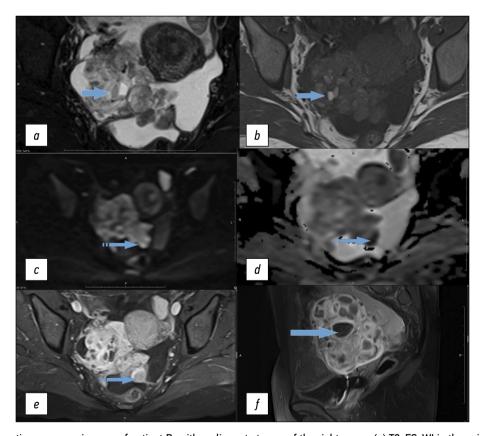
Pelvic magnetic resonance images of patient R. with malignant struma of the right ovary: (a) T2-FS-WI in the axial plane; (b) T1-WI in the axial plane; (c) diffusion-weighted imaging (b = 1,000); (d) apparent diffusion coefficient map; (e) T1-FS-WI + contrast in the axial plane; (f) T1-FS-WI + contrast in the sagittal plane. The solid arrow indicates colloid nodules in the malignant struma of the right ovary. The dotted arrow shows lesions along the pelvic peritoneum with increased paramagnetic accumulation and restricted diffusion similar to the solid component of the primary tumor.
